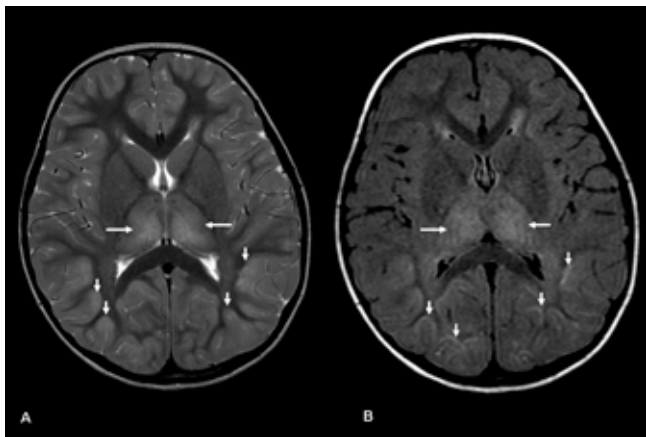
Axial T2-weighted and FLAIR images at the level of the basal ganglia show T2 hyperintensity and swelling of the thalami (long arrows) and cortical/subcortical high signal within the parieto-occipital regions bilaterally (short arrows).
